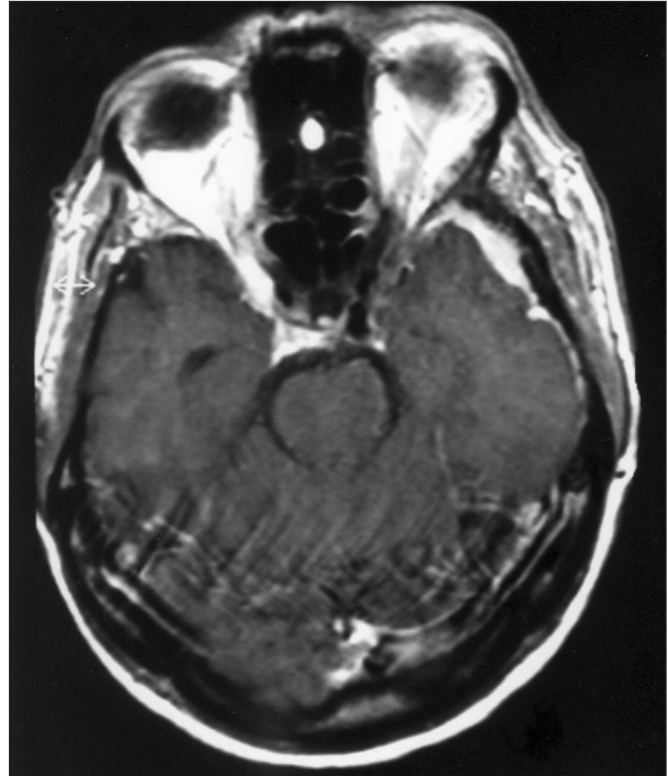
Postoperative magnetic resonance imaging of the orbit and brain with gadolinium 2 years after the operation. No recurrence of the en plaque meningioma is observed. The intraorbital part of the tumor remains unchanged.
